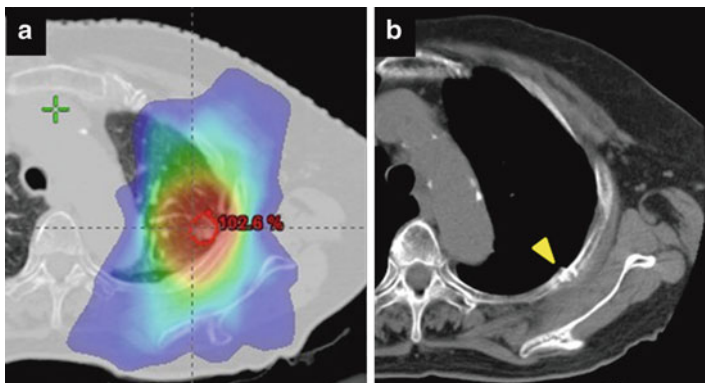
Asymptomatic rib fracture developed at 24 months after SBRT. (a) Isodose distribution prescribed with 48 Gy in 4 fractions at isocenter, (b) CT image 18 months after SBRT. A yellow arrow shows the SBRT-induced rib fracture with a linear sclerotic change and discontinuity of the cortex
